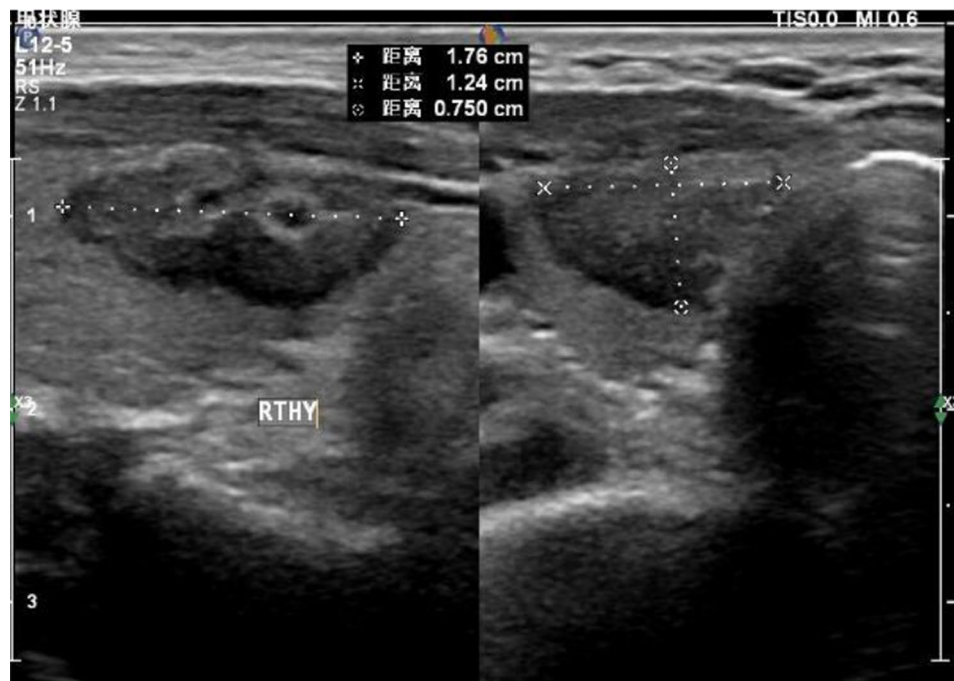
Ultrasound (US) showed changes in the right lobe of the thyroid gland after ablation
